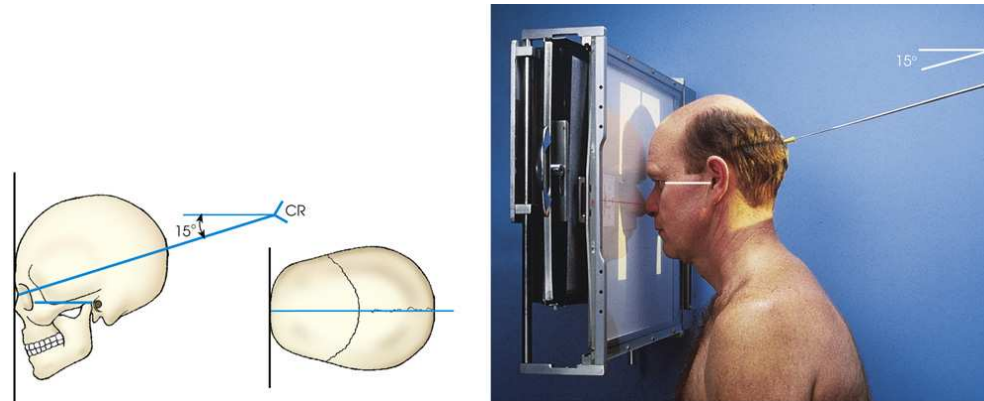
Upright radiography, PA axial facial bones: Caldwell method.
